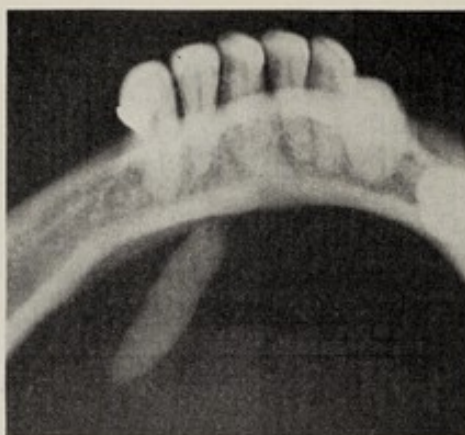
Radiograph of calculus in Wharton's duct.
